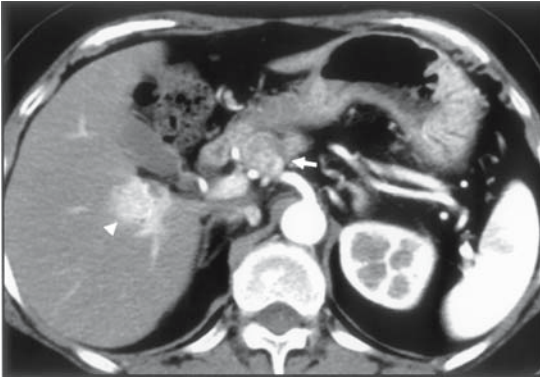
Imaging findings of an oncocytic pancreatic endocrine tumor (PET) (Contrast-enhanced CT (CE-CT), early phase). A solitary mass (arrow) extending from the body to the head of the pancreas is identified by contrast-enhanced CT imaging as a mildly enhancing mass. Metastatic lesion in the liver is strongly enhanced (arrowhead).
